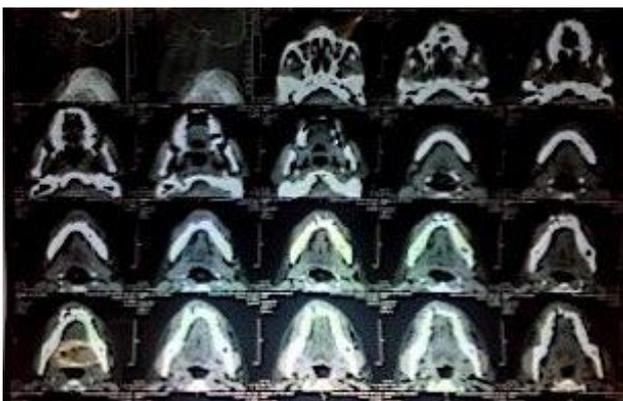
Axial section of CT Scan showing lesion in maxilla
